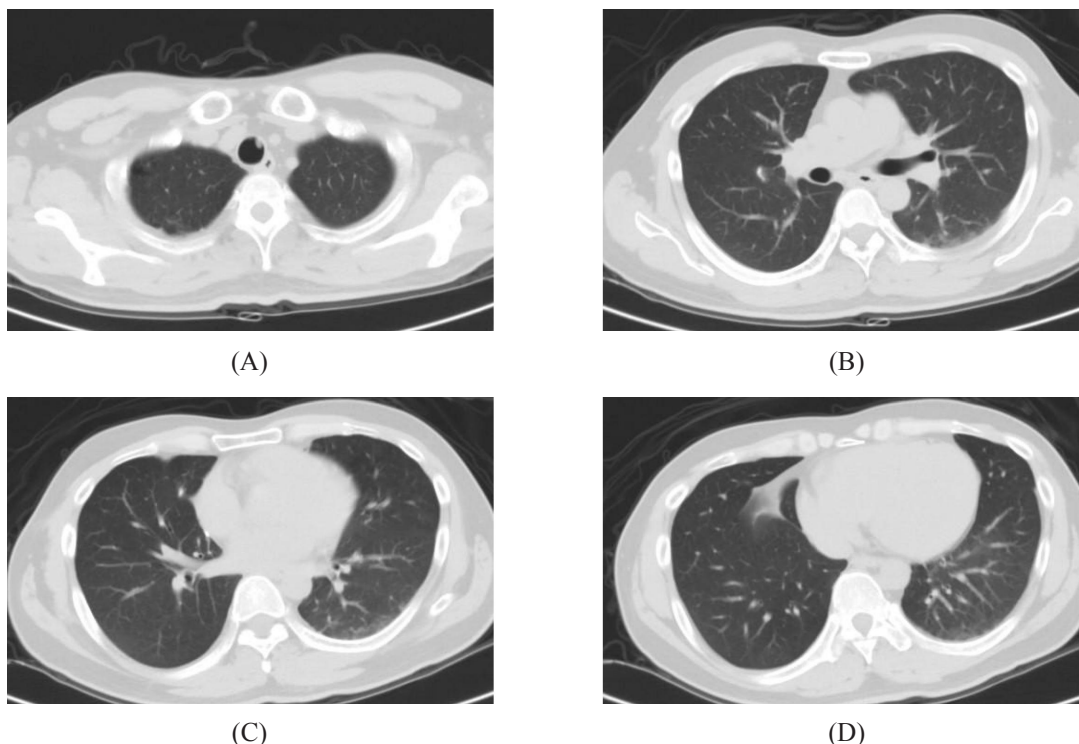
Follow-up chest CT 2 months later showed resolution of the diffuse ground glass opacity.
